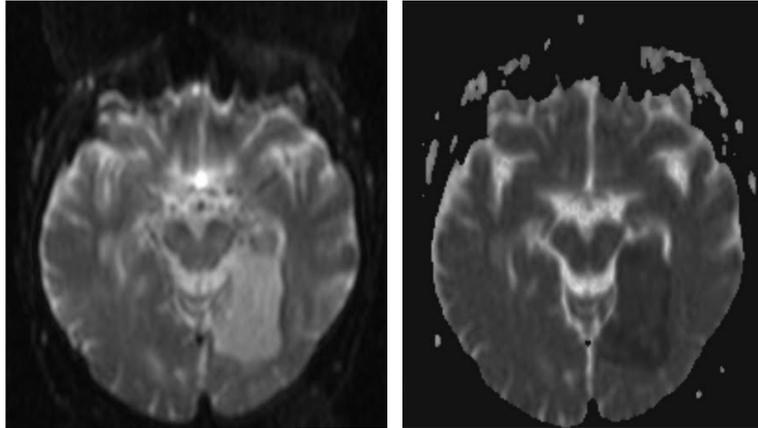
Diffusion weighted Imaging (DWI) slices [23]
